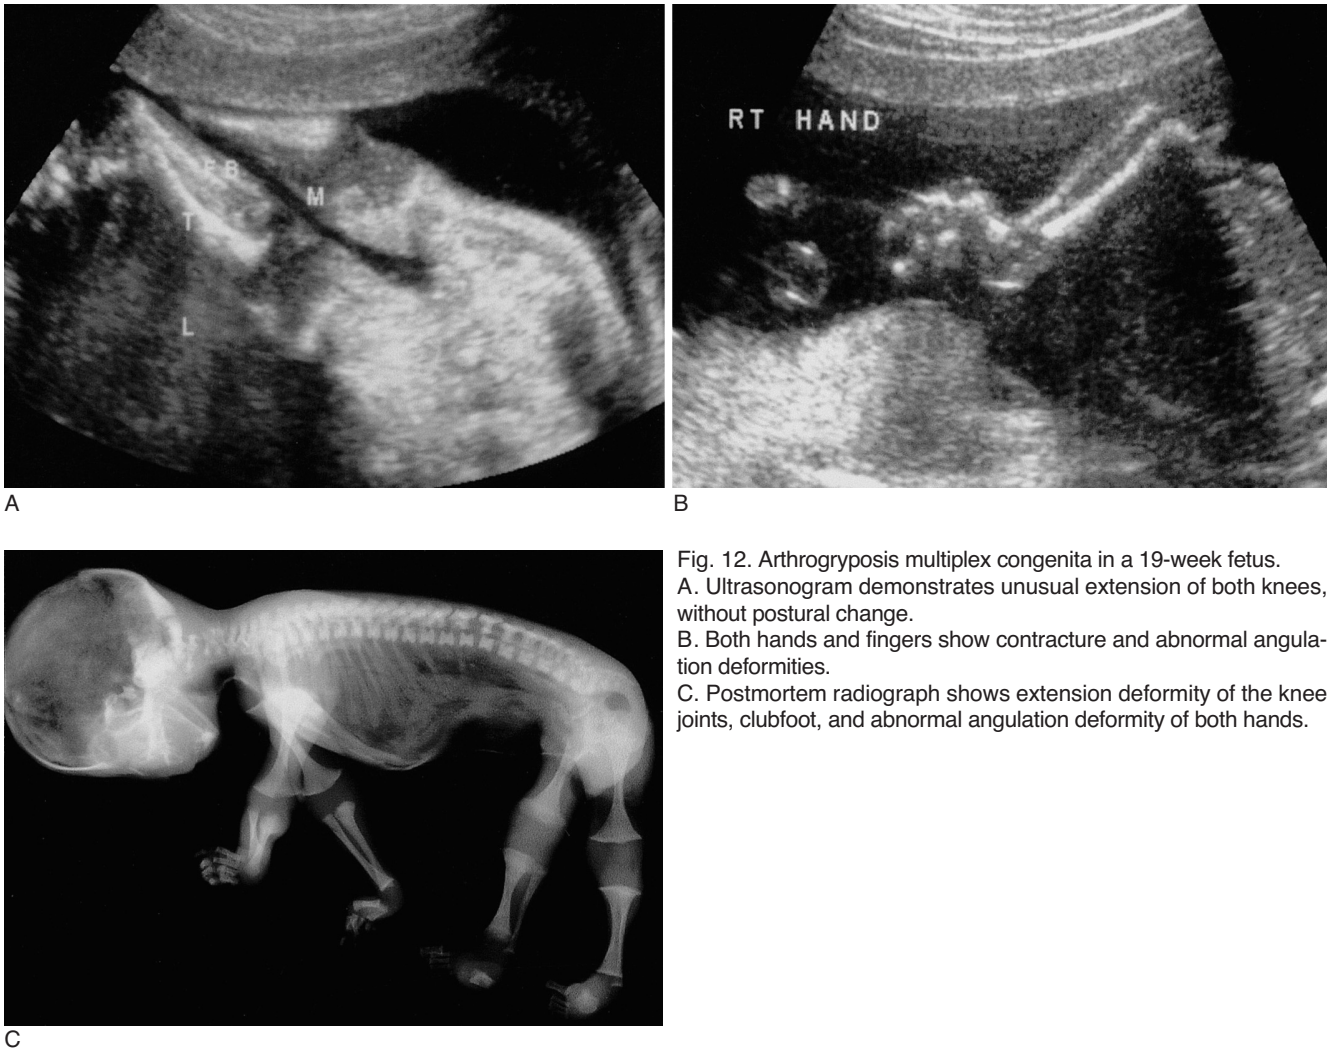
Arthrogyrosis multiplex congenita in a 19-week fetus. A. Ultrasonogram demonstrates unusual extension of both knees, without postural change. B. Both hands and fingers show contracture and abnormal angulation deformities. C. Postmortem radiograph shows extension deformity of the knee joints, clubfoot, and abnormal angulation deformity of both hands.
